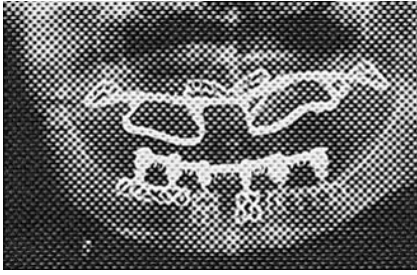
A postoperative panoramic roentgenogram indicates locations of vital struts and extensions.
